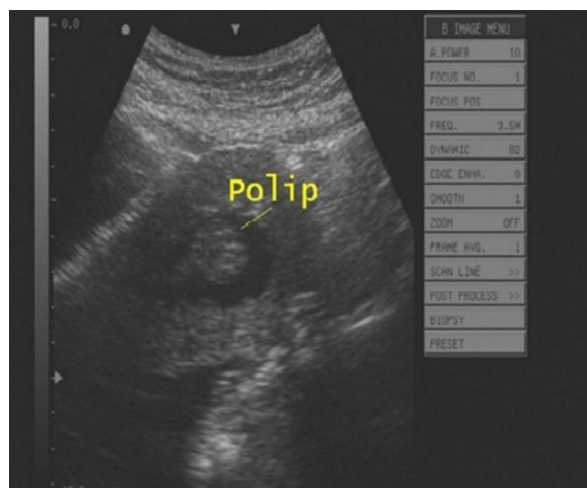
Intrauterine intervention under ultrasound guidance; polyp appearance.
